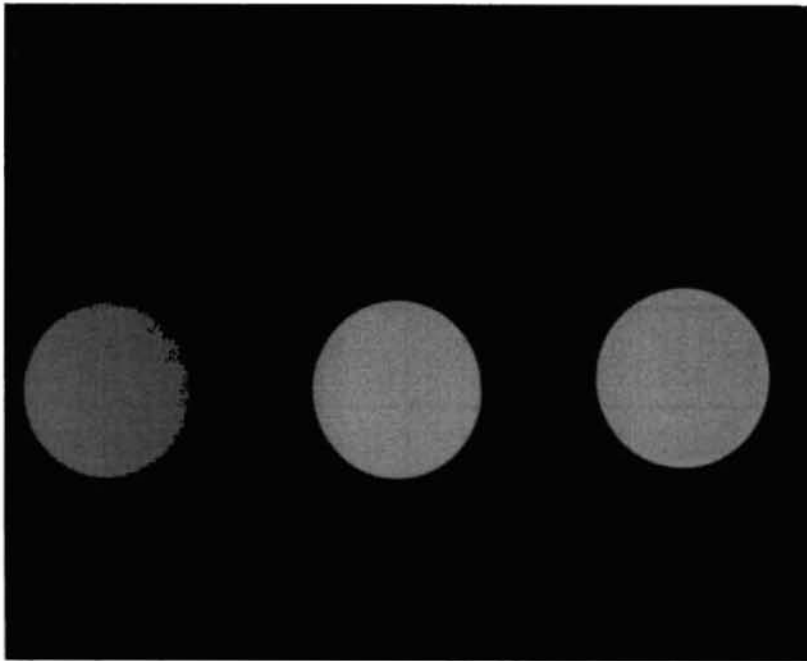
X-ray photographs of NR-BS systems at concentrations varying from 50 - 150 phr
